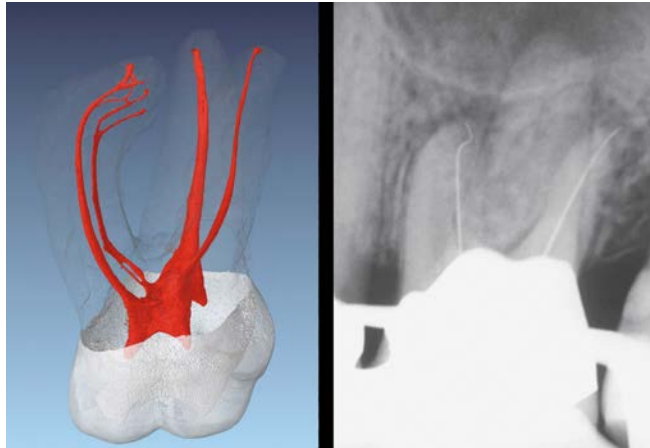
Left: A μ CT image of a maxillary molar demonstrates challenging root canal system anatomy (Courtesy of Dr. Frank Paque; Zurich, Switzerland). Right: A working film of a maxillary first molar demonstrates size 10 files at the radiographic terminus (RT). Note the MB1 apical one-third recurvature.
